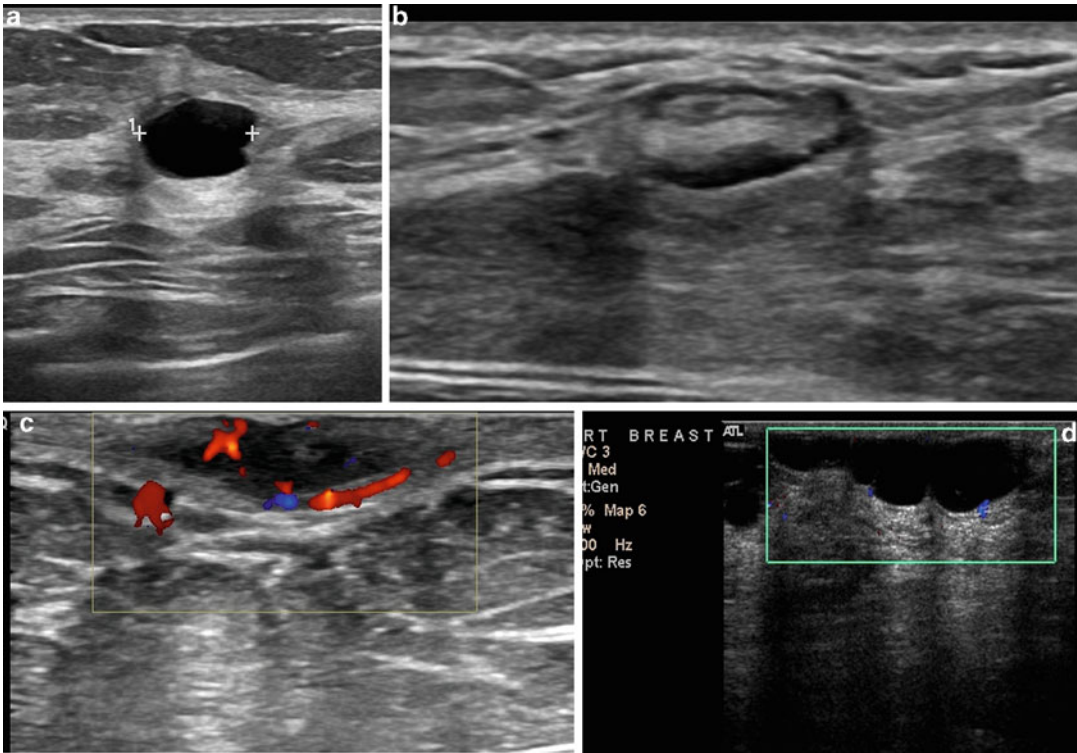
Benign causes for palpable lumps diagnosed by sonography, no further work up is needed. (a) Cyst. (b) Lymph node. (c) Infected epidermal cyst. (d) Thrombosed superficial vein in Mondor's disease of the breast
